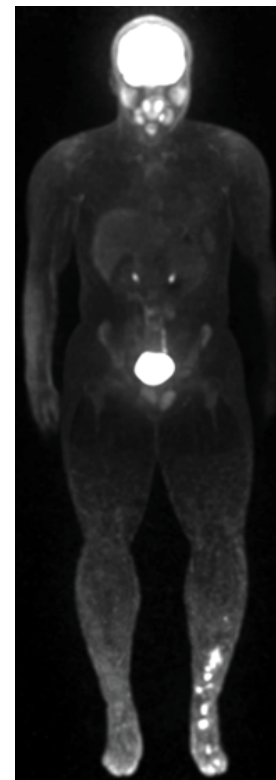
Whole-body FDG PET maximum-intensity projection (MIP) and fused PET-CT images demonstrate hypermetabolic lesions corresponding to the known sites of disease within the distal left lower extremity. No additional FDG-avid lesions are identified elsewhere in the body, confirming confinement of disease to a single extremity.
